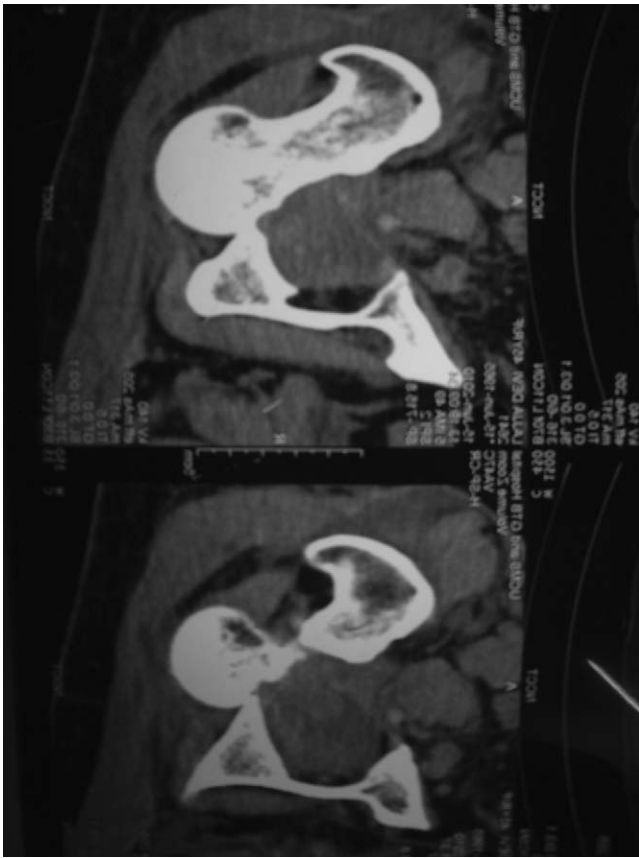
CT scan axial images showing posterior dislocation of the hip.
